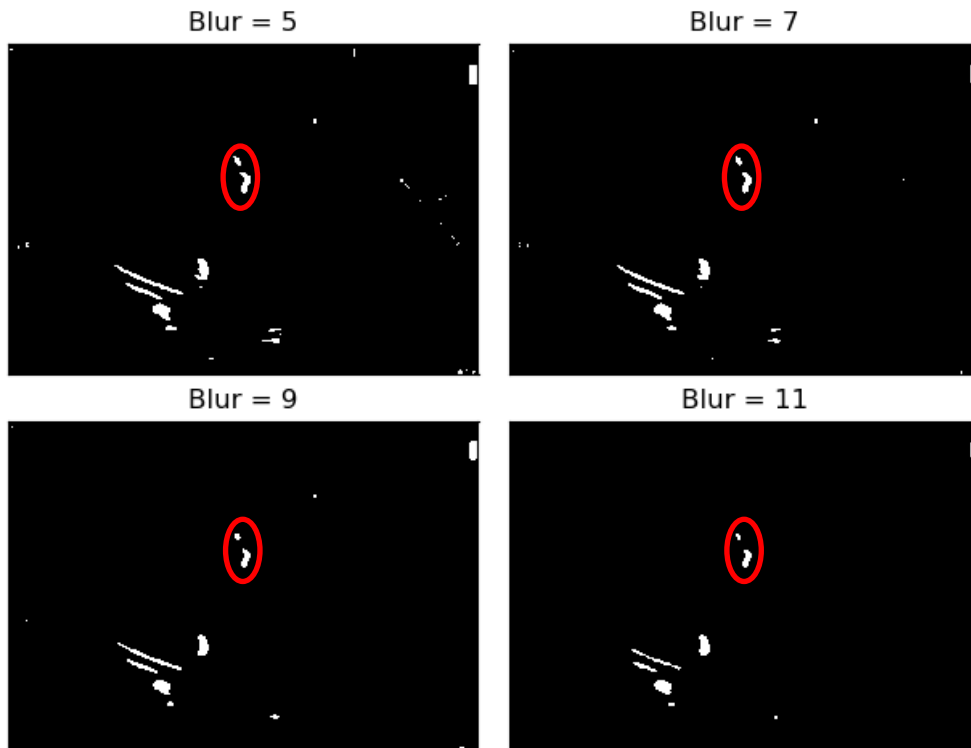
Binarization of an echocardiography image, for each size of the kernel parameter
